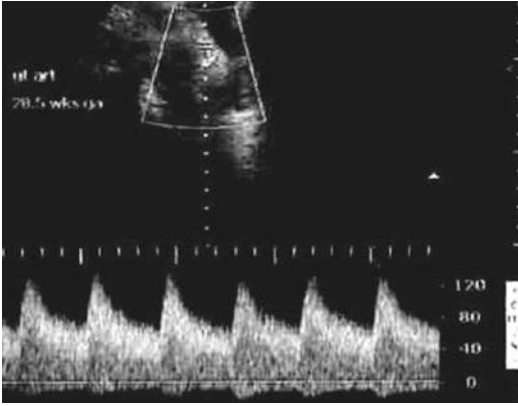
Normal uterine Doppler waveform with good diastolic flow in 28.5 weeks' pregnancy
